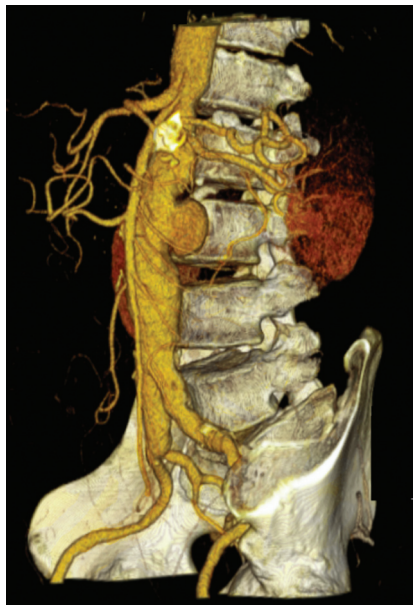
CTA. Three dimensional reconstruction of a saccular abdominal aortic aneurysm
